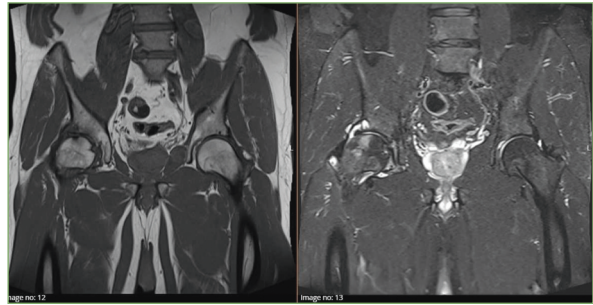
T1 (right) and short tau inversion recovery sequence (left) images of the right hip coronal section T1-weighted series, hypo-, T2-weighted series and hypo-and hyperintense signal changes
